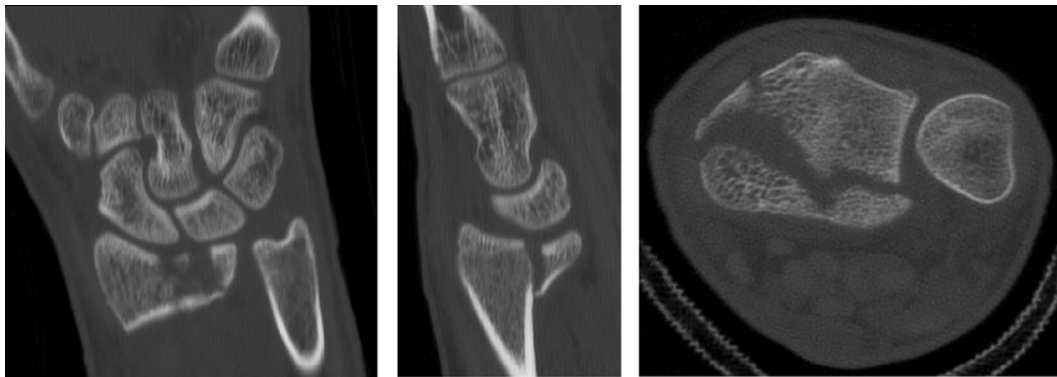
CT scan showing displacement of volar lunar facet with volar radiocarpal subluxation.
